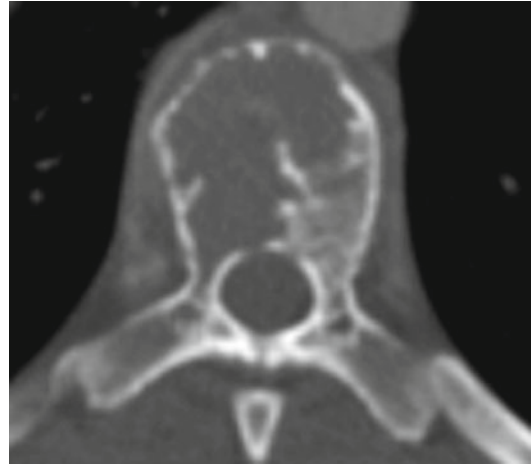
Axial view of CT scan showing a lytic lesion with no bony matrix centered in the vertebral body. Additional images show endplate fracture
